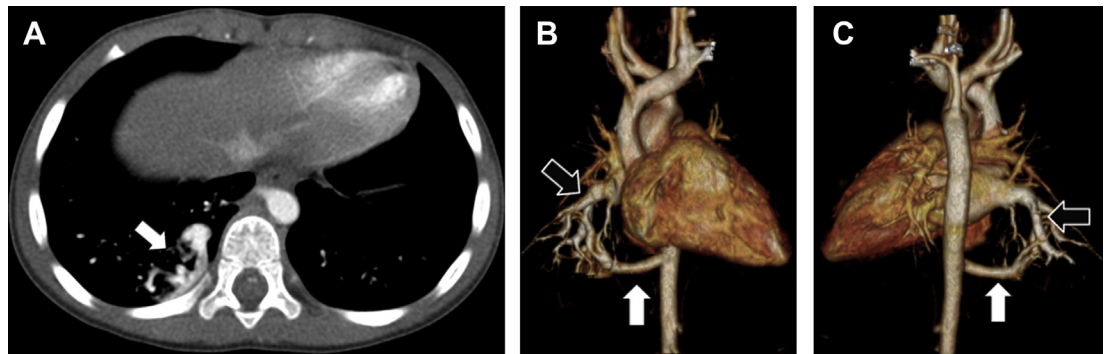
A 21-month-old boy with intralobar bronchopulmonary sequestration. (A) Axial contrast-enhanced CT demonstrates a heterogeneous lesion in the right lower lobe containing large abnormal vessels (*arrow*). (B, C) 3D volume-rendered CT images show systemic feeding artery (*white arrows*) arising from the aorta and venous drainage (*black arrows*) to the pulmonary veins and left atrium.
